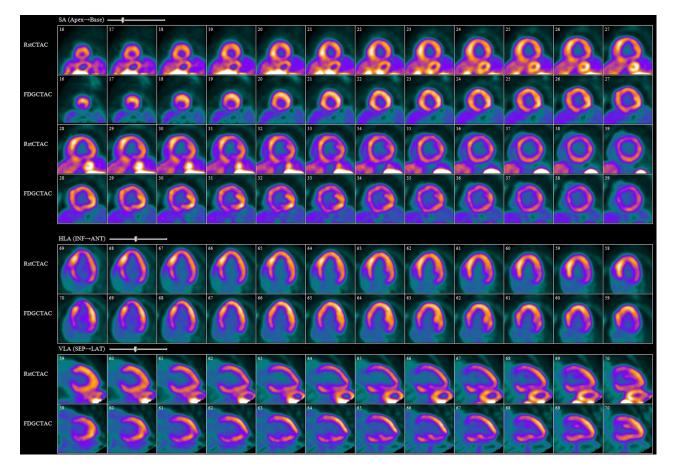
Non-diagnostic cardiac PET F18-FDG due to failure to suppress myocardial FDG uptake evidenced by global FDG uptake of the myocardium (above: resting Rb82 perfusion; below: F18-FDG images which show diffuse myocardial uptake of F18-FDG).
